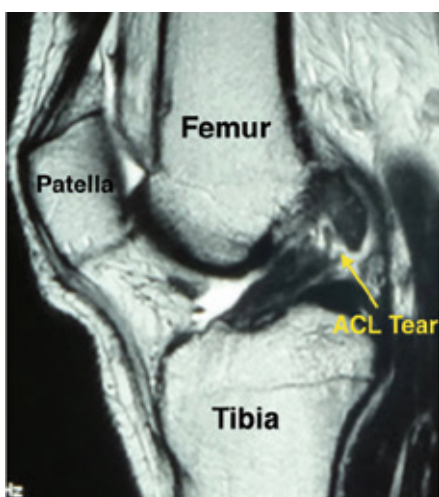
Single sagittal MRI image of the knee demonstrates a tear of the anterior cruciate ligament.
